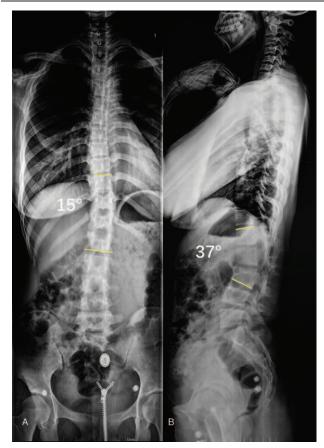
Upright radiographs of the whole spine of the proband's older sister. (A) Anteroposterior radiograph showing a Cobb angle of 15° at T10-L1. (B) Sagittal radiograph showing a Cobb angle of 37° at L1 to L3.
